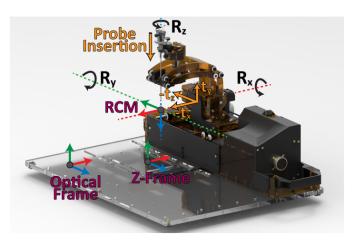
The registration frames and motions of the robot developed by Nycz et. al [2]. A fiducial z-frame placed under the robot's base is used for MRI registration and an optical frame is used for accuracy assessment registration.
